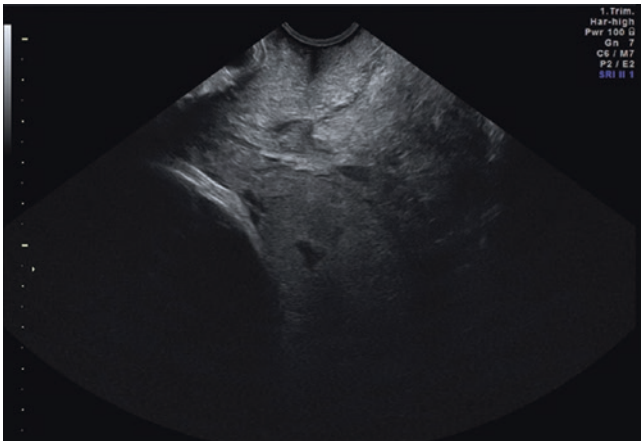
Transvaginal ultrasound: placenta previa in the third trimester
